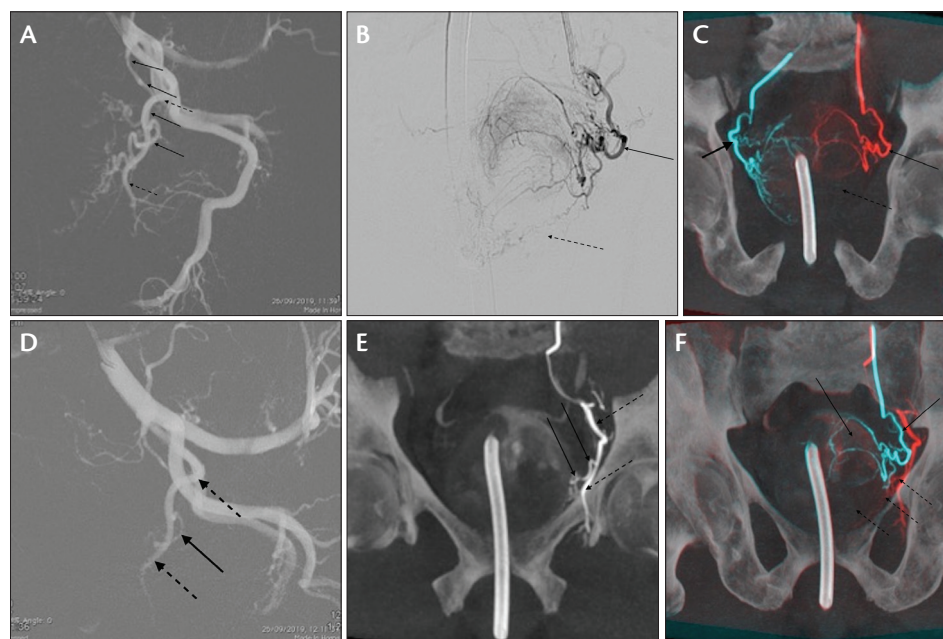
Left anterior oblique view (35° with caudal-cranial angulation -10°) road map of the left internal iliac artery depicting the left prostatic artery (arrows) overlapping with the obturator artery (dashed arrows; A). Posteroanterior DSA after selective catheterization of the left prostatic artery (arrow) denoting lack of vascularization of the inferior third of the left central gland of the prostate (dashed arrow; B). CBCT coronal reformat overlaid imaging after selective catheterization of the left prostatic artery (arrow) and right prostatic artery (solid arrow), denoting the asymmetric lack of vascularization of the inferior third of the left central gland of the prostate (dashed arrow; C). Left anterior oblique view (35° with caudal-cranial angulation -10°) road map of the left obturator artery (dashed arrows) depicting a second left prostatic artery (arrow; D). CBCT coronal reformat confirming a second left prostatic artery (arrows) vascularizing the lower third of the central gland arising from the obturator artery (dashed arrows; E). CBCT coronal reformat overlaid imaging after selective catheterization of the left prostatic artery vascularizing the upper two-thirds of the central gland (arrows) and the left prostatic artery vascularizing the lower third of the central gland (dashed arrows; F).
